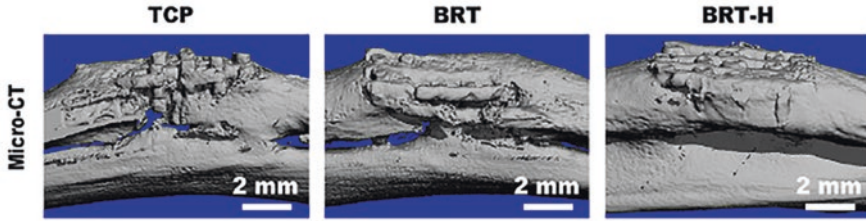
Micro CT images of increased bone regeneration in a segmental bone defect with implantation of BRT-H scaffolds observed after 12 weeks. The hollow scaffold (BRT-H) performed better when compared with the solid scaffold and a control tricalcium phosphate (TCP) scaffold. (Reprinted with permission from [38] LN-4916780135691)
